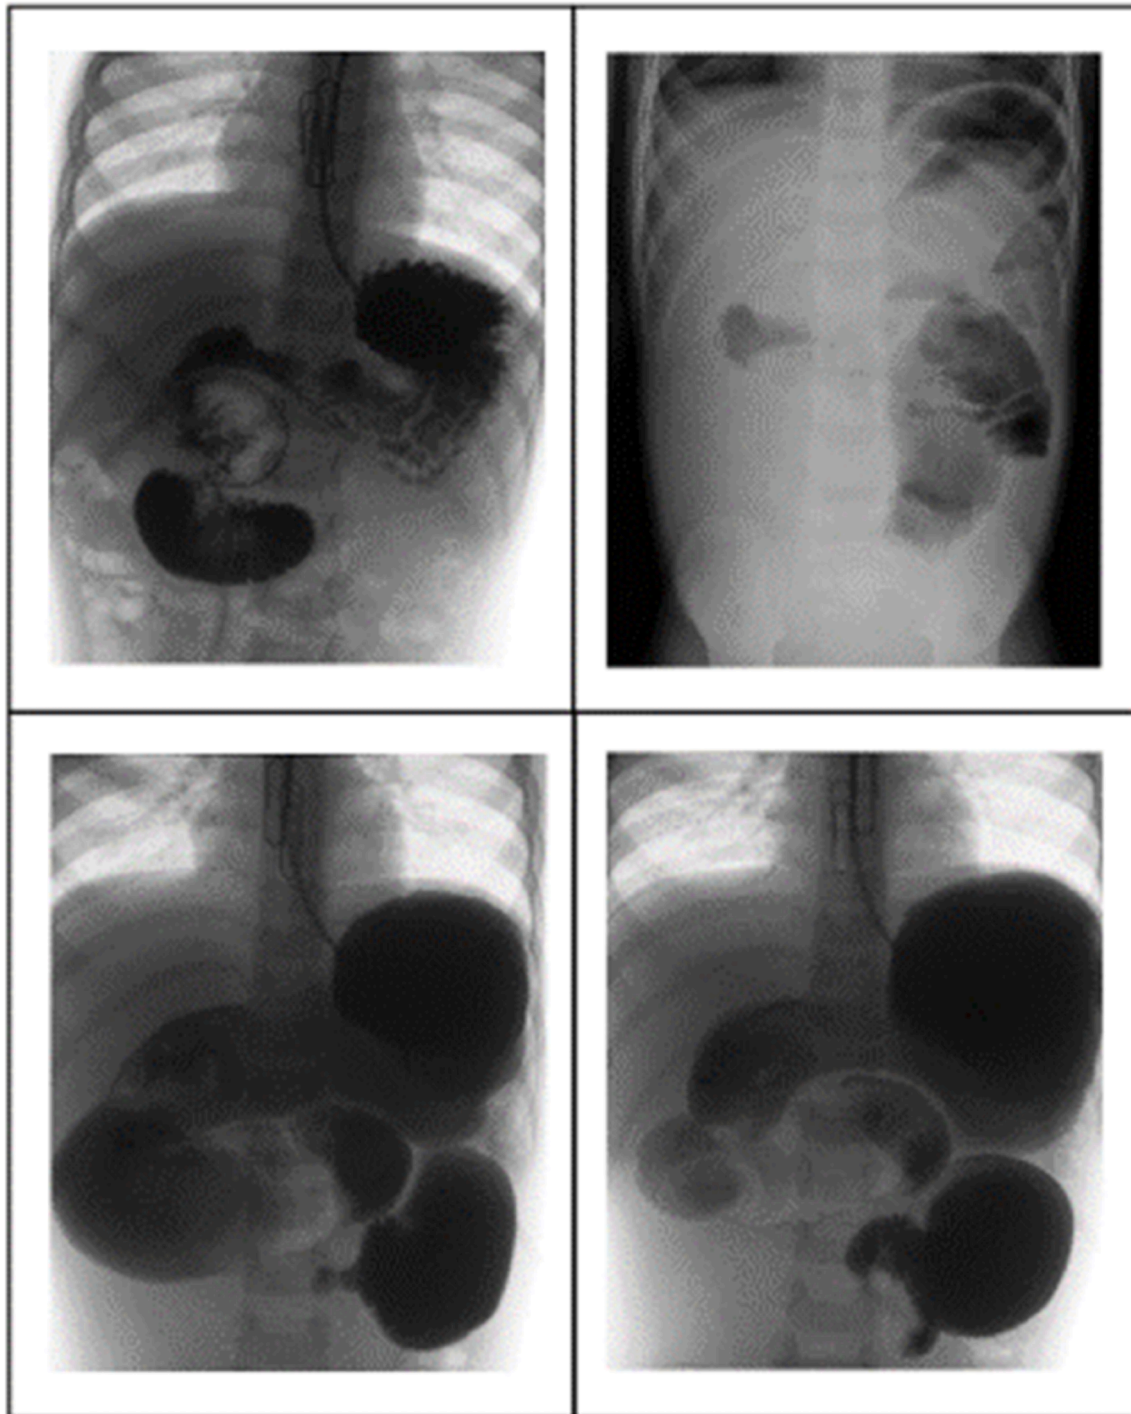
Peri-operative image of a 3 year 5 month old child with clinical concern of malrotation demonstrating contrast within the stomach and duodenum in (a). Pre-operative images: a nasogastric tube was used to instill contrast. Note the placement of metallic markers to demarcate the midline. The DJ flexure is right of the midline and the duodenum is distended consistent with malrotation which was surgically confirmed. Images (b), (c) and (d) are post-operative images. Abdominal radiograph (b) shows dilated loops of small bowel in the left abdomen. Fluoroscopic images (c and d) demonstrate a tight stenosis in the proximal jejunum with subsequent marked dilatation of the duodenum. The duodenum has a cork-screw appearance suggestive of duodenal volvulus. DJ = Duodenojejunal.
